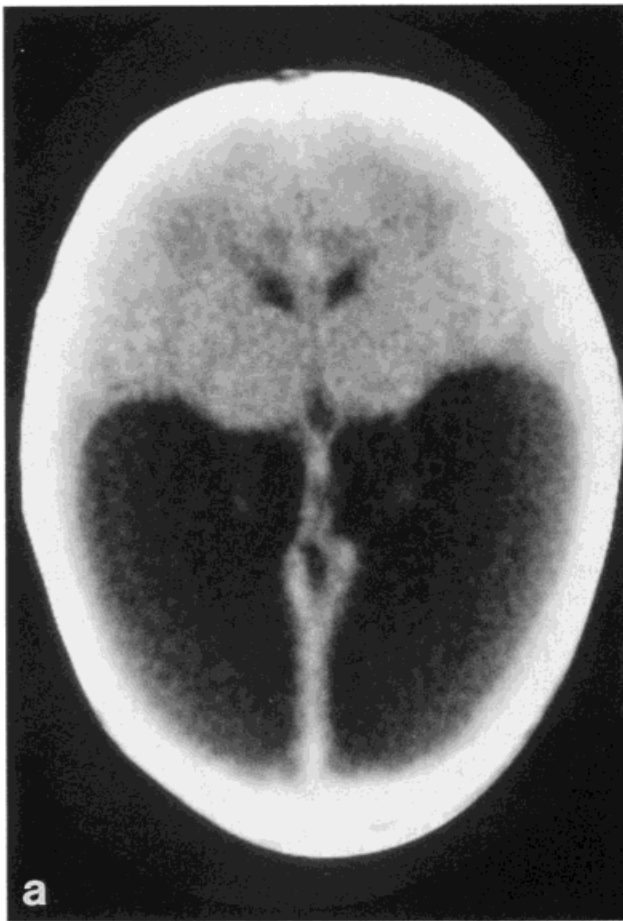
a: Axial CT brain scans of L.G. Note enlarged occipital horns with mild asymmetry L > R, age 1 day. b: Note enlarged temporal horns and a normal third ventricle, age 1 day. c: Post shunting of both lateral ventricles. Note decompression and normal fourth ventricle, age 4 years.
